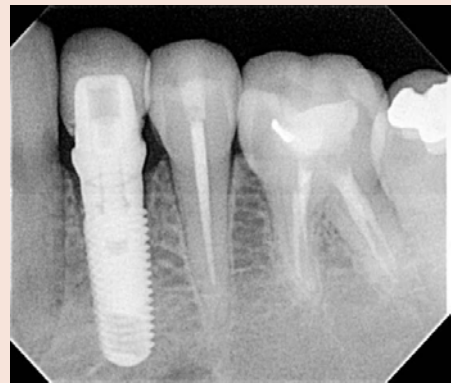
Radiograph of the immediate implant after placement.
